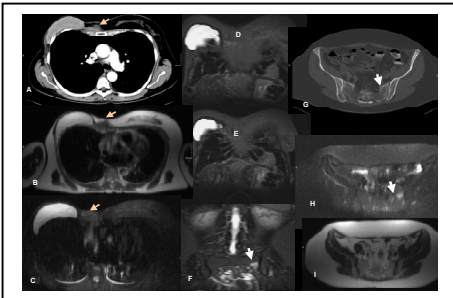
Axial continuously moving Whole Body-MRI (Moving During Scan) using STIR (c) and HASTE/STIR (b) demonstrated a recurrent disease of breast cancer in the right chest wall in concordance to the CT-findings (a). Coronal multi-station Whole Body-MRI failed to detect a relapse (d, e), however coronal multi-station Whole Body-MRI detected a skeletal metastases of the pelvis (f) confirmed by CT (g), axial continuously moving Whole Body MRI using STIR-sequence (h). The axial continuously moving Whole Body MRI using a HASTE-sequence was false negative indicating no lesion (i).
